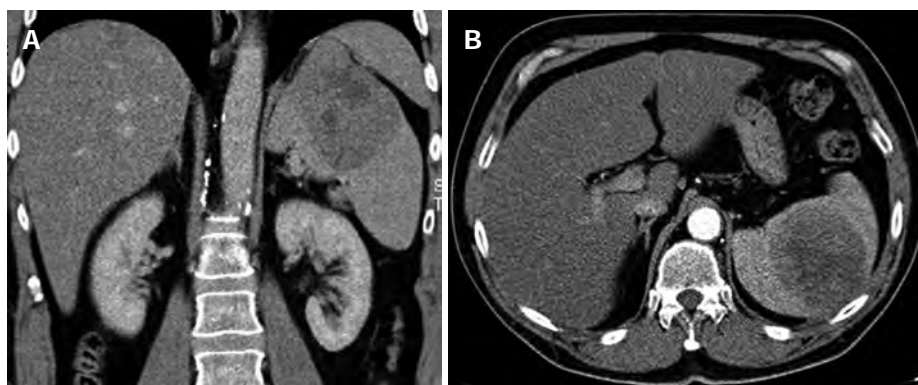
Tumor (10 cm × 8 cm × 6 cm) on the upper pole of the spleen. A: Computed tomography scan, arterial phase with a coronal reconstruction; B: Computed tomography scan, arterial phase - axial orientation.
